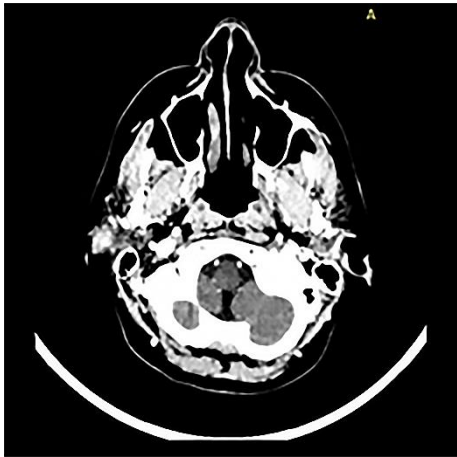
CT scan, axial section
